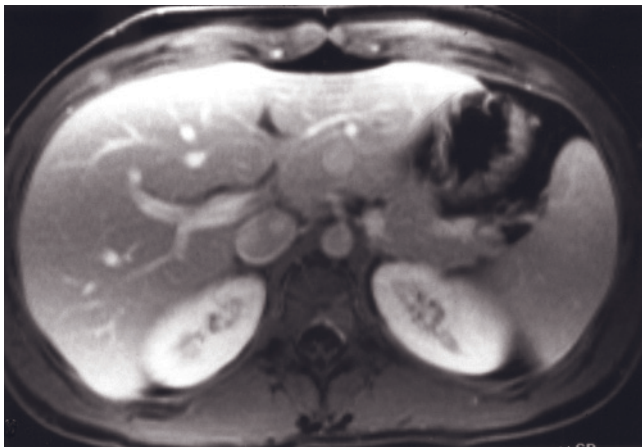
Liver and pelvis protocol. Coronal T2-weighted single-shot echo-train spin-echo (a), coronal T1-weighted SGE (b), T2-weighted fat-suppressed single-shot echo-train spin-echo (c), T2-weighted breath-hold STIR (d), T1-weighted out-of-phase SGE (e), T1-weighted in-phase SGE (f), hepatic arterial dominant phase SGE (g), 1-min postgadolinium SGE (h), 1.5-min postgadolinium
